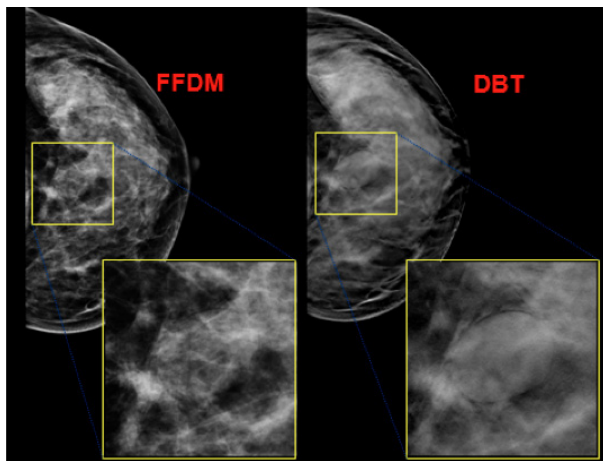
DBT Images for the Bright Ring Around the Mass. The figure report of X-ray demonstrated BI-RADS: 4A. The pathological report revealed fibroadenoma.
